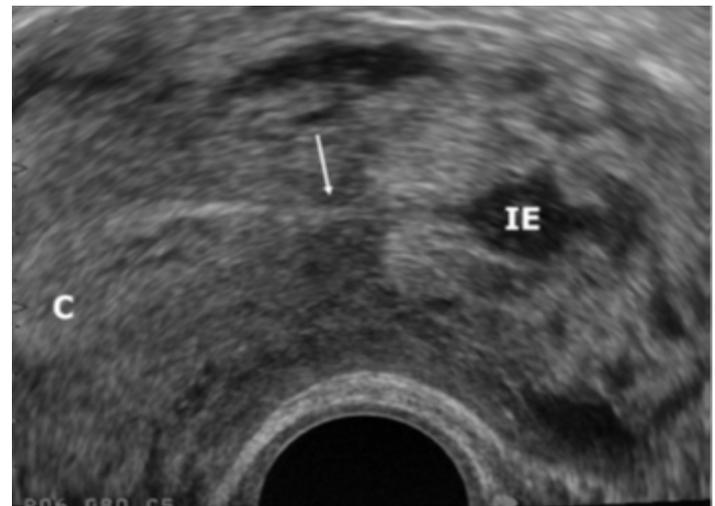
Ultrasound findings of Interstitial ectopic pregnancy (IE), Interstitial line sign (echogenic line) is seen (arrow) joining the endometrial cavity (c) ¹⁹.
